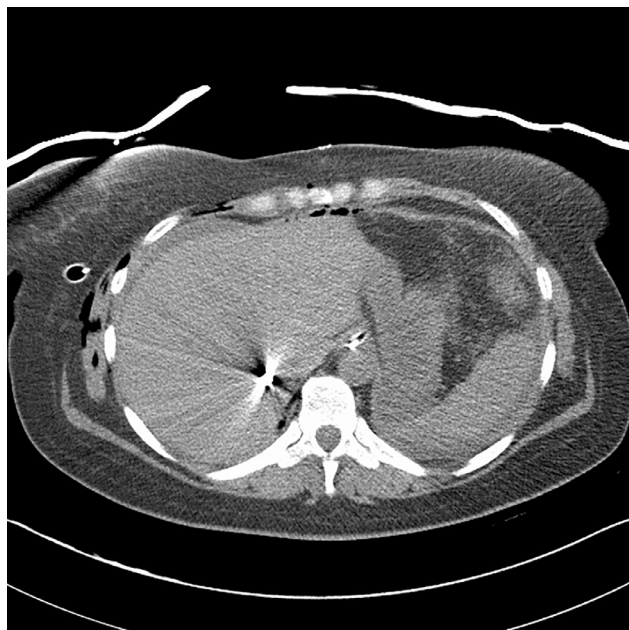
Noncontrast CT of the abdomen at the level of the hepatic veins showing bullet embolus in close proximity to the IVC.
